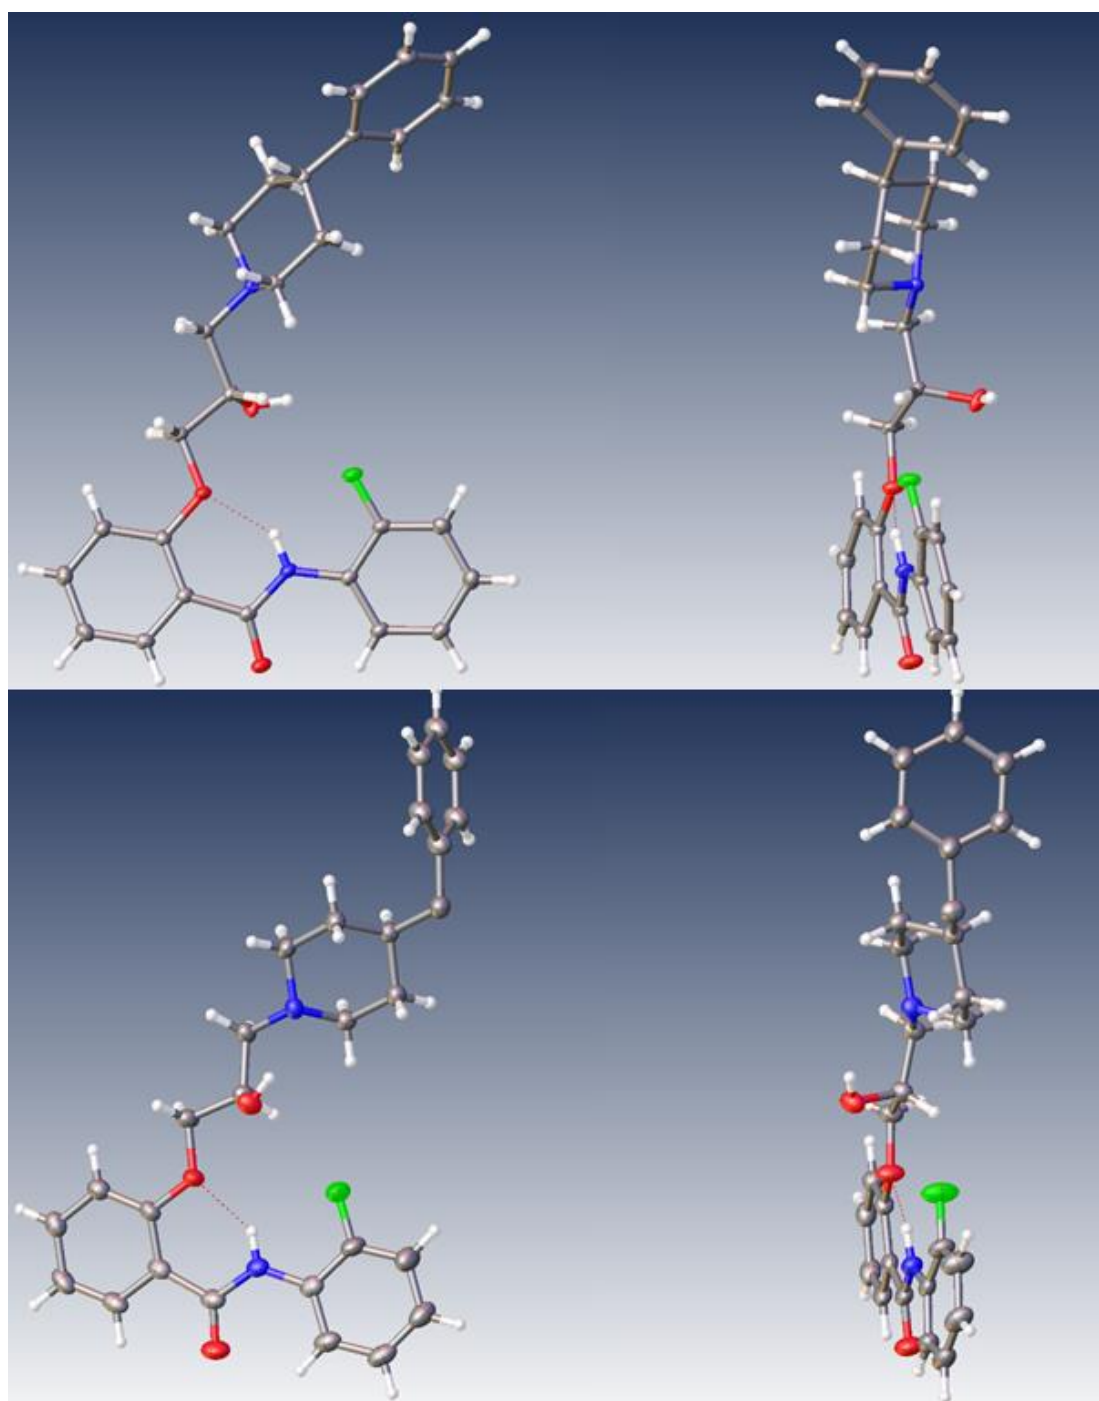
X-ray structures of 184 (top row) and 188 (bottom row) in two angles each.
